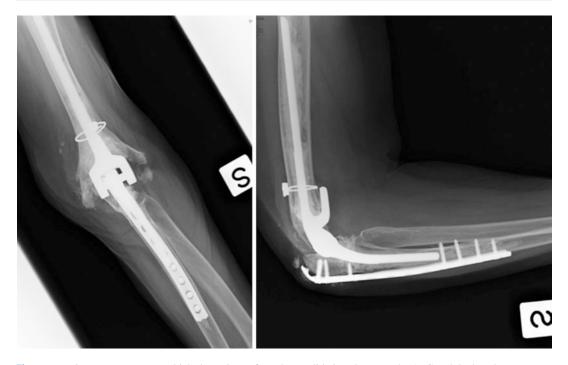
One year Fu X-rays which show signs of good consolidations between the APC and the host bone
